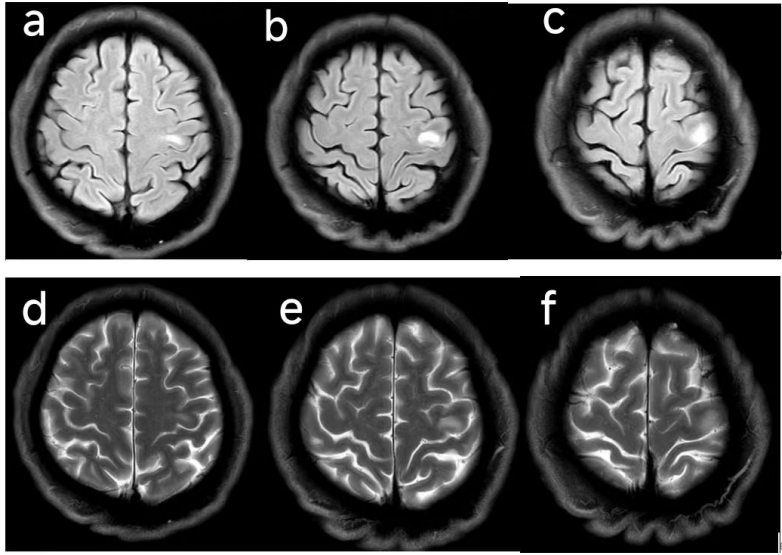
(a~c) FLAIR sequence, (d, f) T2 sequence, high signal shadow of T2-FLAIR in the central anterior gyrus of the left frontal lobe, slightly high signal on T2WI, no enhancement of the lesion
